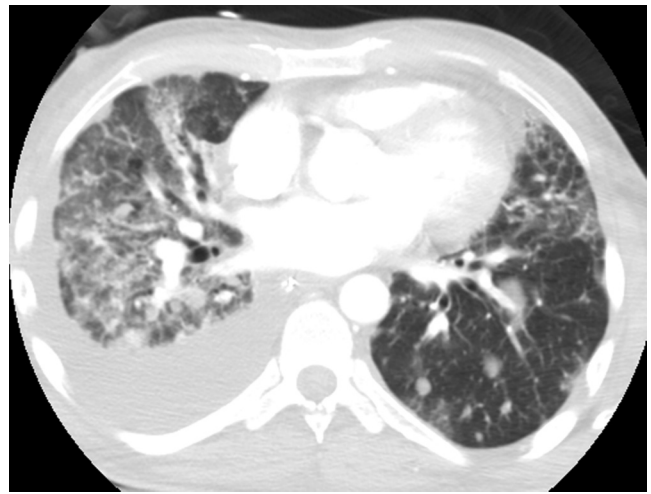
38-year-old male with metastatic choriocarcinoma. Transverse CT image from a CT pulmonary angiogram obtained 9 days prior. Again demonstrated are the numerous pulmonary nodules of metastatic choriocarcinoma. However, the lucent halos are absent. Also seen is the large right pleural effusion for which a chest tube was placed, leading to the initial, trace pneumothorax.
